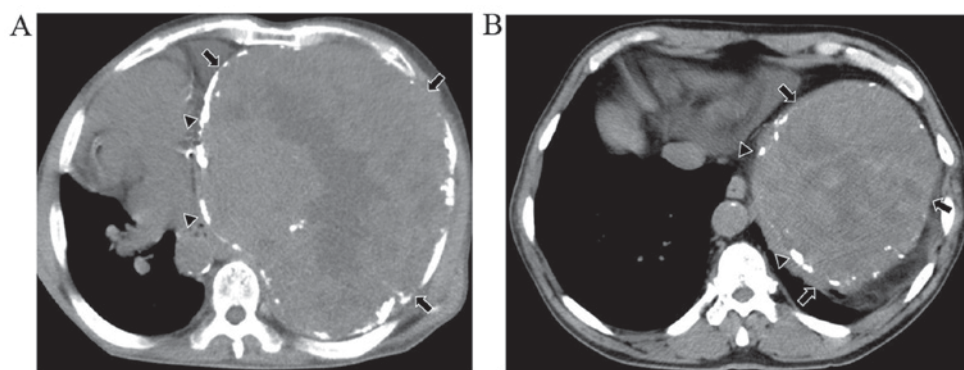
(A) Chest CT scan at the admission to the University of Tsukuba-Mito Kyodo General Hospital showed a mass of inhomogeneous density (arrows) with focal calcification within the mass (triangles). (B) Chest CT scan taken 9 years before the patient's mortality. CT, computed tomography.
